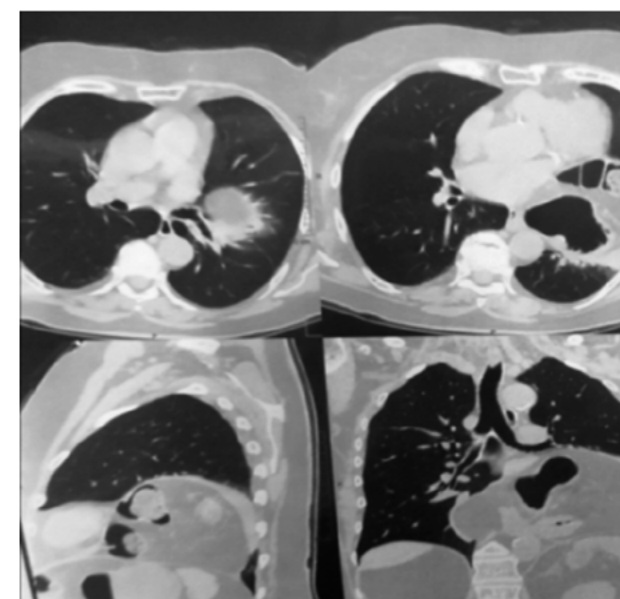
CT-signs of a giant hernia of the diaphragm
